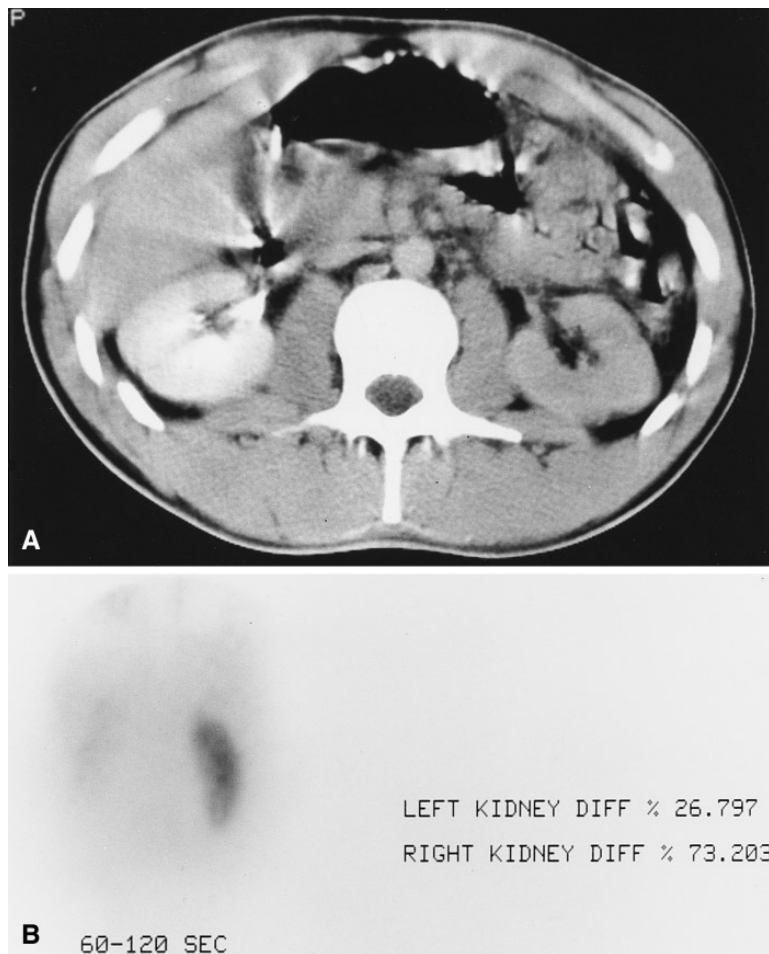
A Contrast-enhanced CT scan of the abdomen prior to stent placement shows decreased perfusion to the left kidney which demonstrates no excretion of contrast. B A nuclide scan 9 days after left renal artery stenting shows 27% uptake on the left. This was unchanged from the present scan, but the hard copy of that scan was lost.
